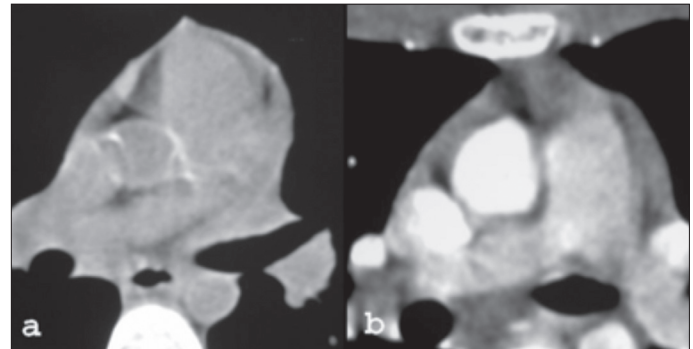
A) A nonenhanced computed tomographic scan shows that the entire ascending aorta is diffusely calcified B) A contrast-enhanced computed tomographic scan in the upper portion of the ascending aorta shows the irregularity of the intimal surface of the ascending aorta
